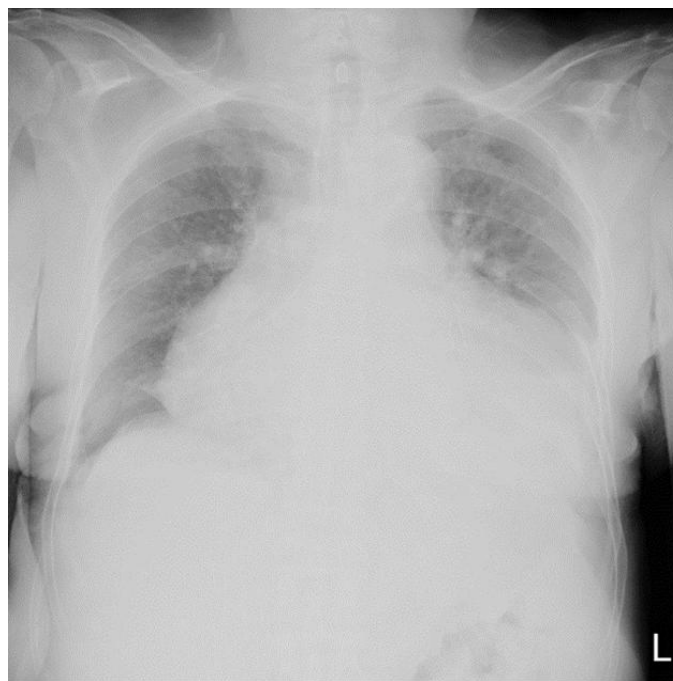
Pneumothorax. The radiograph reveals increased transparency of the enlarged right costophrenic angle, known as the “deep sulcus sign”, which is indicative of a pneumothorax. It is accompanied by visualizing a visceral pleural line without distal lung markings. Additionally, there is a blunted appearance at the tip of the right costophrenic angle, suggesting the presence of minimal ipsilateral pleural effusion or hydropneumothorax. Notably, a chest tube is correctly positioned at the right costophrenic angle.
